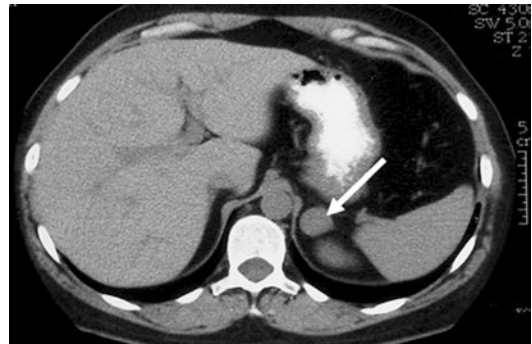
CT-scan of a left adrenal adenoma (white arrow) incidentally discovered
